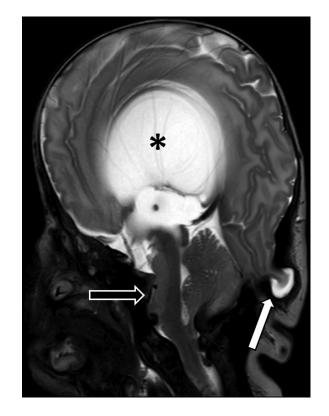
Sagittal T2-weighted MRI of the brain reveals marked ventriculomegaly (asterisk), severe crowding of the hindbrain structures (white arrow), and extension of the left occipital lobe into the posterior calvarial protrusion (white arrow).
